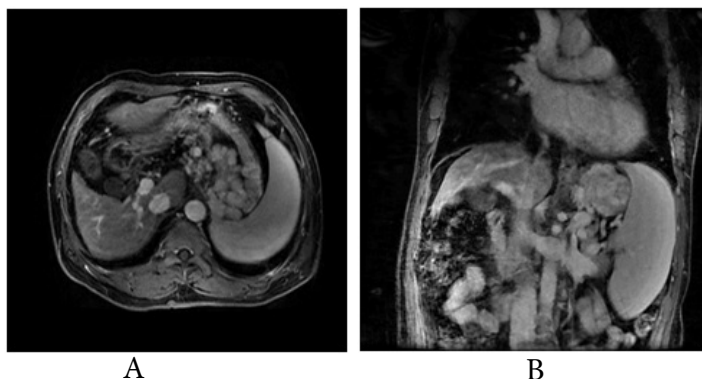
Imaging of gastric varices: a) MRI images showing the giant GV and b) prominent GRS.
